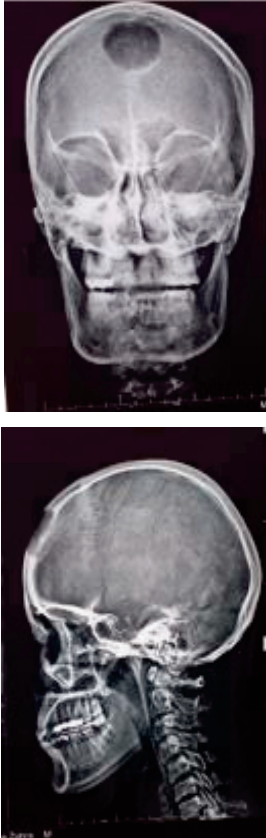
standard X-ray revealed a frontal bone gap
